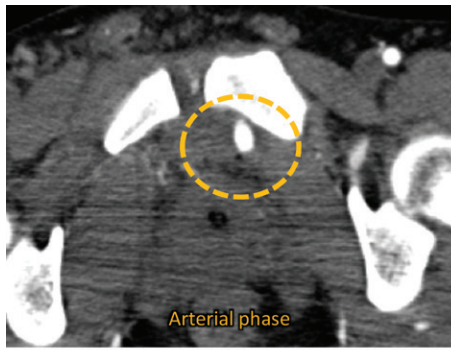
Arterial injury patterns: active arterial extravasation in a 40-year-old man. (a) Axial arterial phase CT angiogram of the pelvis shows active extravasation of contrast material (dashed circle) with attenuation at least equal to that of the iliac artery during the arterial phase. (b) Axial venous phase CT angiogram shows an increase in the size of the area of contrast material extravasation (dashed circle).
